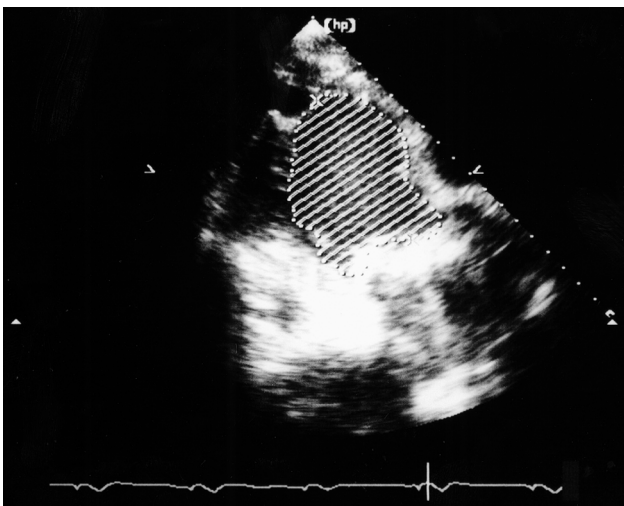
Postoperative echocardiography showed left ventricular end diastolic volume index of 100 ml.
